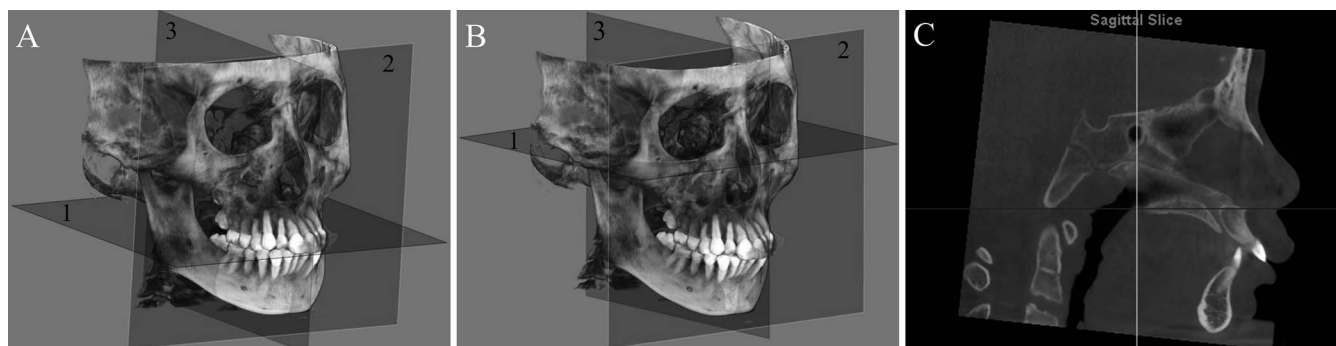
(A) Cone-beam computed tomography (CBCT) orientation for measurement of the Boston University analysis. Plane 1: functional occlusal plane. Plane 2: coronal plane. Plane 3: mid-sagittal plane. (B) CBCT orientation for measurements of the University of the Pennsylvania and Yonsei University analyses. Plane 1: Frankfort plane. Plane 2: coronal plane. Plane 3: mid-sagittal plane. (C) Reorientation of axial plane for measurement of the mid-palatal suture opening distance.
